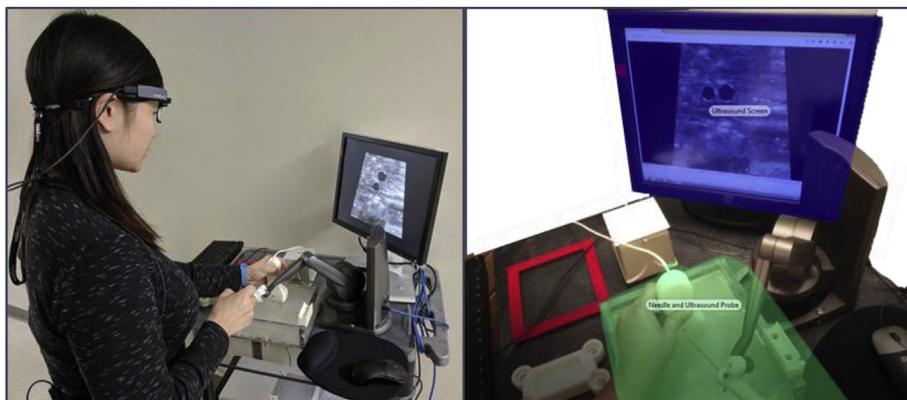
(Left) Experimental setup with participant wearing Tobii Pro Glasses 2 at the DHRT system. (Right) Two main areas of interest (AOIs). The *ultrasound screen* and the *needle and ultrasound probe*.
